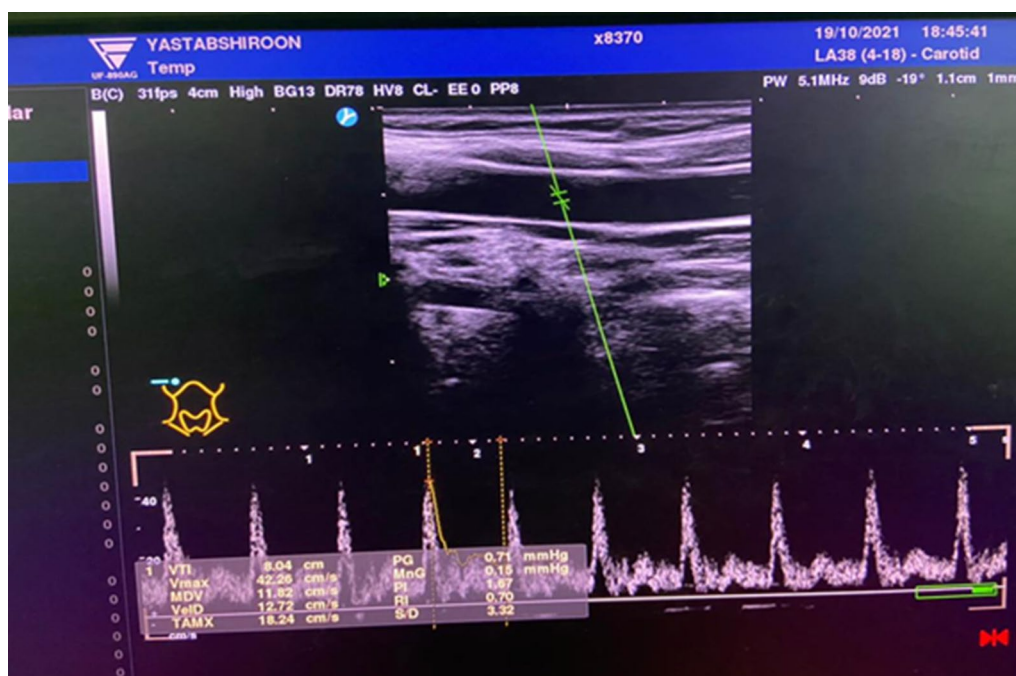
Spectral ultrasound of the common carotid artery shows the Doppler parameters PSV=42.26, EDV=12.72, RI=0.70 and S/D=3.32
